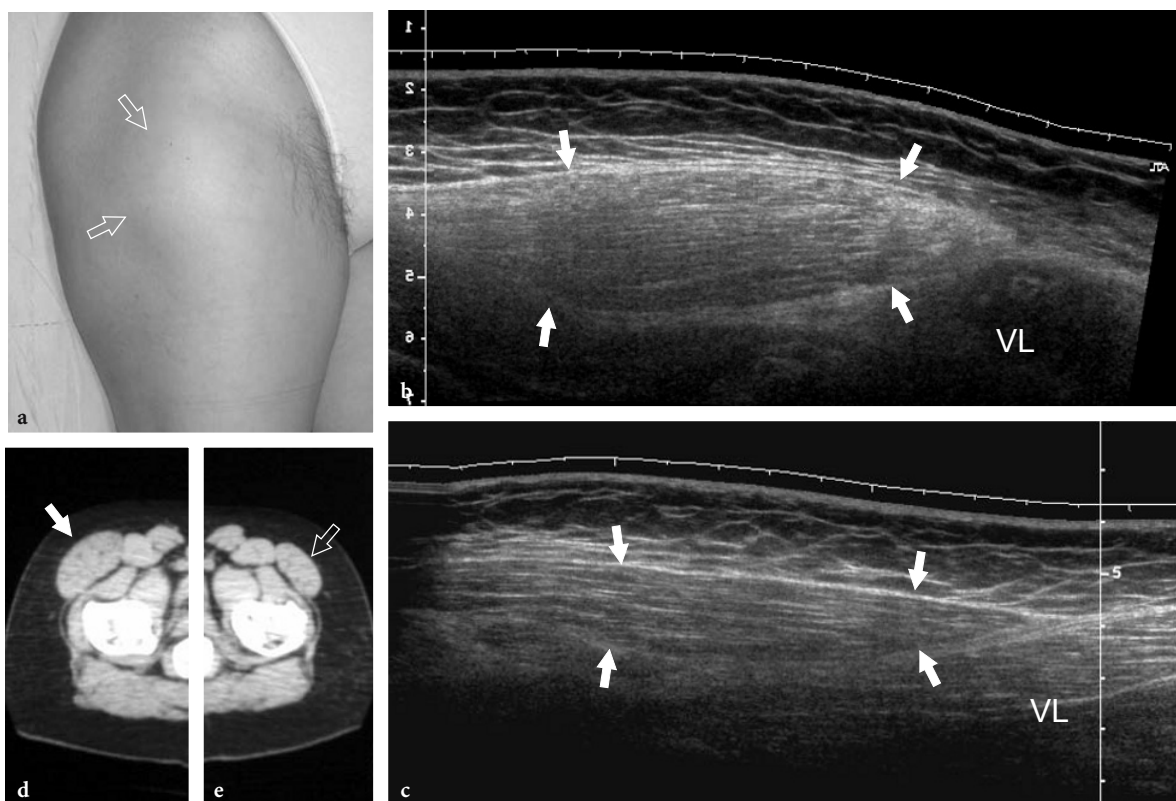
Benign pseudohypertrophy of the tensor fasciae latae muscle. a Photograph of the anterior right thigh of a middle-aged woman presenting with a palpable, non-tender anterolateral lump in the thigh which had been gradually enlarging for a decade. Note that the overlying skin appears normal. b Longitudinal extended field-of-view 12–5 MHz US image obtained over the mass reveals enlargement and increased echogenicity of the right tensor fasciae latae muscle (*arrows*). c Correlative extended field-of-view 12–5 MHz US image obtained on the contralateral side shows a normal tensor fasciae latae muscle (*arrows*). VL, vastus lateralis muscle. d,e Parts of a transverse CT scan of the lower pelvis confirm the unilateral hypertrophy of the right tensor fasciae latae muscle (*white arrow*) in comparison with the left (*open arrow*)
